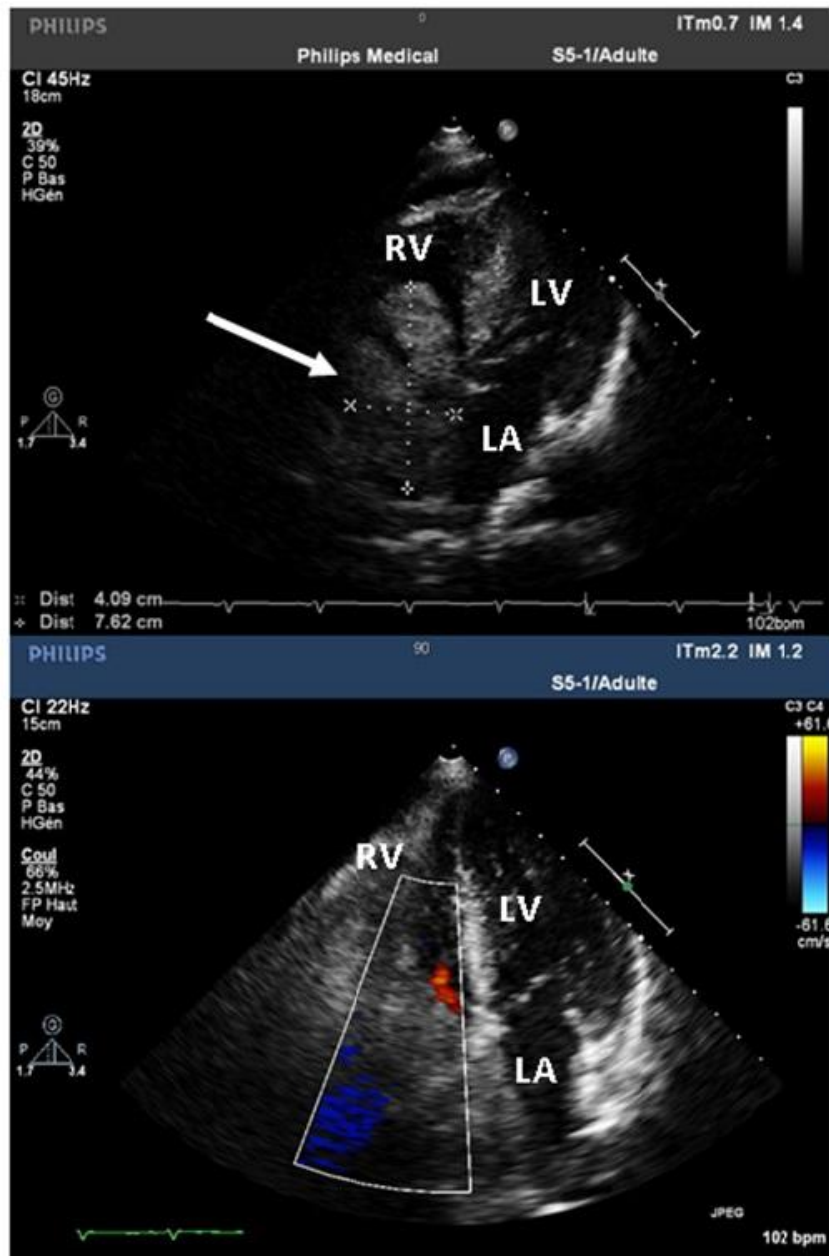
Transthoracic echocardiography showing a vascularized mass in the right atrium prolapsing through the tricuspid valve inside the right ventricle. Arrow, Thrombus; RV, Right ventricle; LV, Left ventricle; LA, Left atrium.
